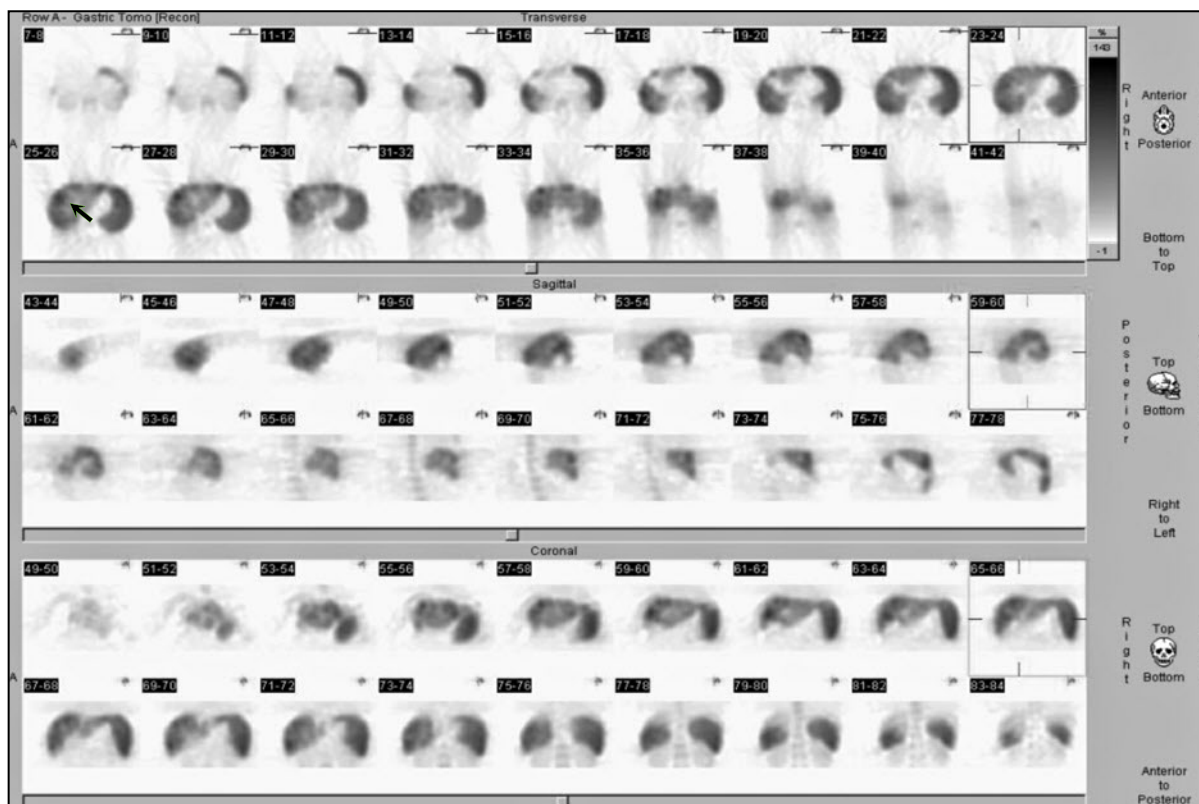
(B) SPECT showing nodular areas in transaxial slices (arrows)
